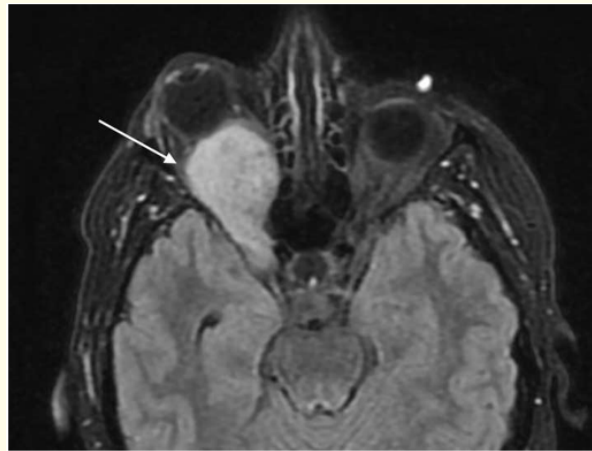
Axial FLAIR image showing a hyperintense, well-defined intraconal mass centered on the right optic canal.
